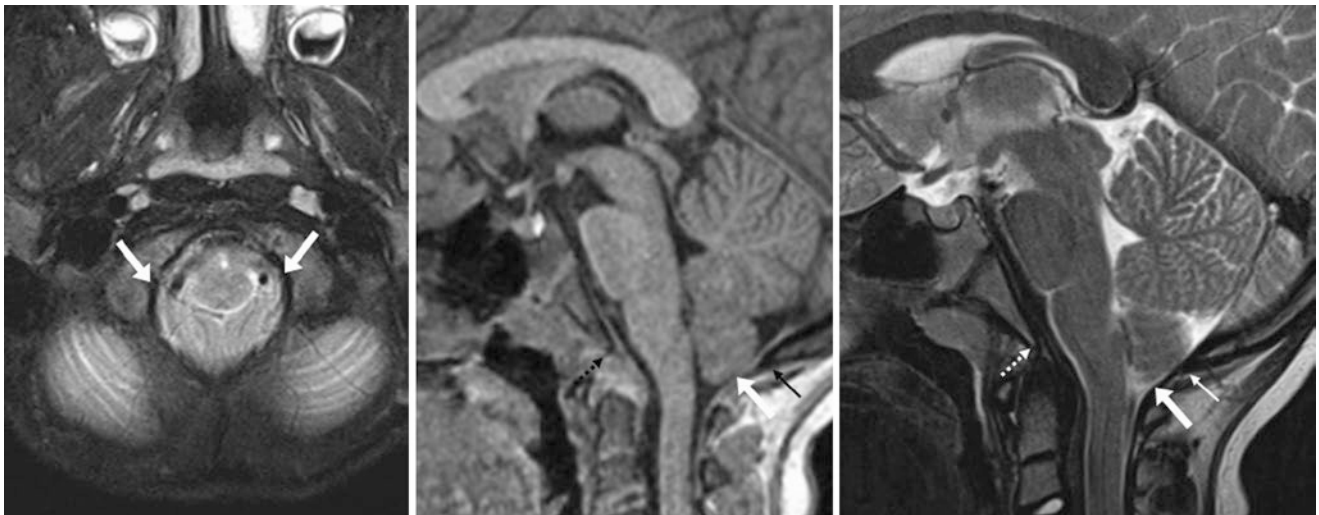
A 7-year-old child with tonsillar ectopia (*arrows*) on an otherwise negative 1.5 T MRI for seizures. On axial T2WI (*left*), there was tonsillar ectopia, with narrowing of the cerebrospinal signal surrounding the cervicomedullary junction, but brainstem or cord compression
